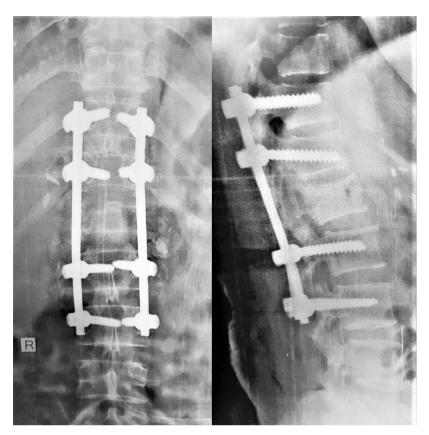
Anteroposterior and lateral radiographs of a patient with L1 vertebra fracture who received LSF.
